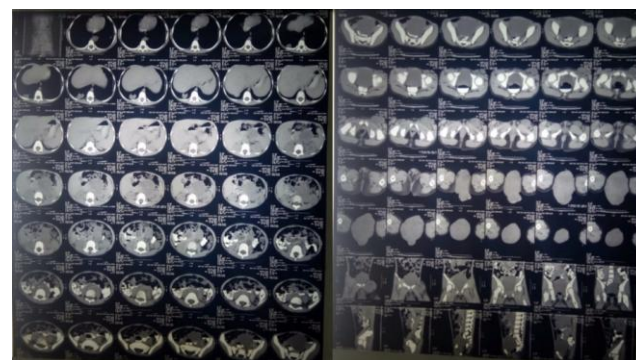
Computed Tomography of Lower Abdomen Pre
